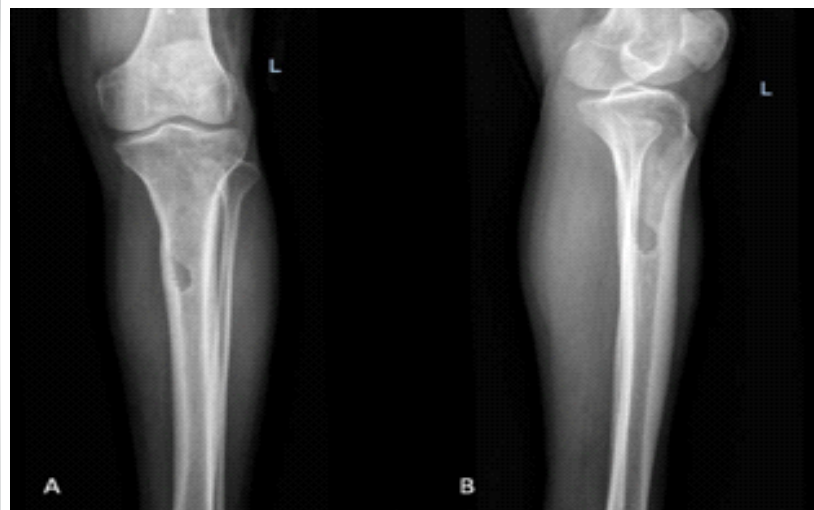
Follow-up radiographs (AP and lateral views) at 6 months showing interval sclerosis and reduction in the intramedullary cavity, with no evidence of progression or cortical destruction.
